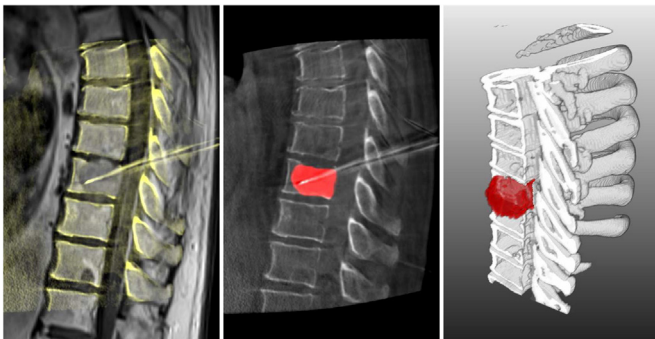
Fusion of pre- and intra-operative images could become a significant improvement of the intervention routine. As a result of the image registration (left; background: MRI, overlay: Dyna-CT) a transformation matrix could be used to transfer and display pre-interventionally produced information like contoured metastases within the intra-interventional images (middle, right).
